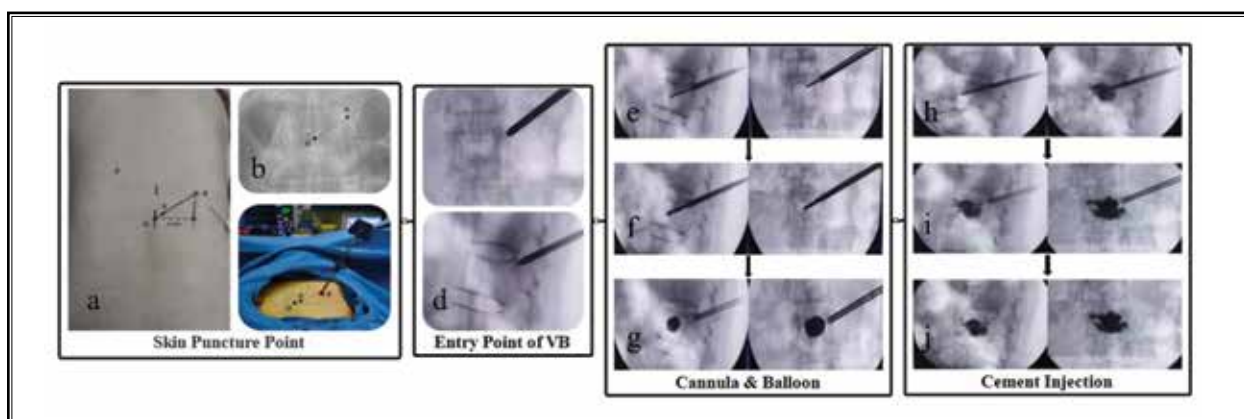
The instruction of procedures of modified unilateral extrapedicular PKP in detail. (a-c) The establishment of skin puncture point during surgery. Point O was the projection of center point of VB, and Point A was the projection of entry point of VB. The skin puncture point, Point B, was determined along Line OA at the distance of x cm measured preoperatively. (d) The entry point of VB was located at the superolateral part of the pedicle on AP view, and the slightly superior part of the junction between the pedicle and VB on lateral view under fluoroscopy. (e-g) The tip of the working cannula was advanced to anterior part of VB across the midline. Then the balloon was inserted and expanded to restore AVH. (h, i) The bone cement was slowly injected into VB until cement reached posterior one-fourth of VB or cement leakage was observed under fluoroscopic monitoring. Ensuring that no cement following the bone filler when pulling it out. (j) AP and lateral radiographs showed the proper bilateral cement distribution during surgery. PKP, percutaneous kyphoplasty; VB, vertebral body; AVH, anterior vertebral height; AP, anteroposterior.
